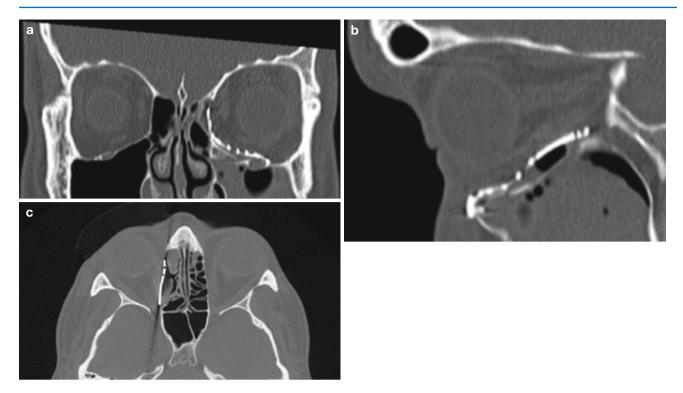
Postoperative CT showing satisfactory plate position (a–c)
